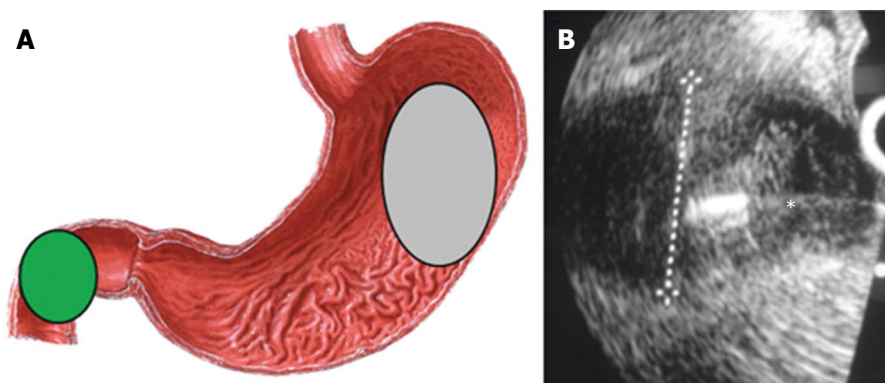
The right kidney image. A: Endoscopic ultrasound positioning and access for tissue sampling; B: Fine needle aspiration of a renal lesion. The asterisk is over the needle to show the fine needle aspiration of the tumor.
